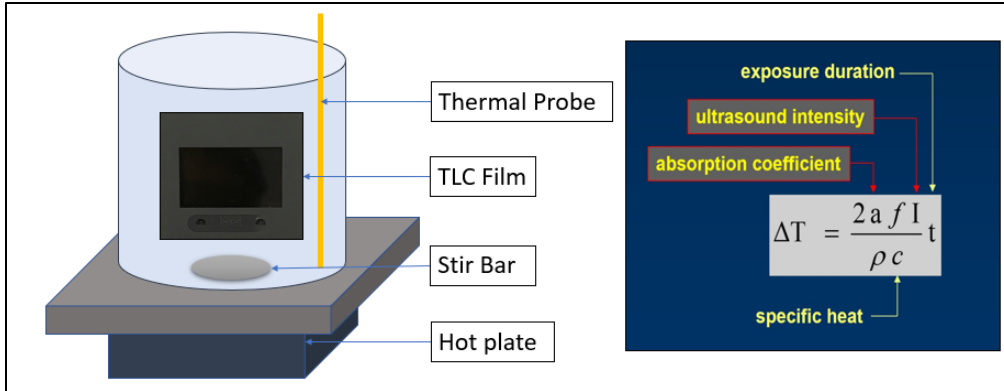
Future work. Right: TLC film calibration experiment; Left: Relationship between temperature change and intensity of ultrasound
